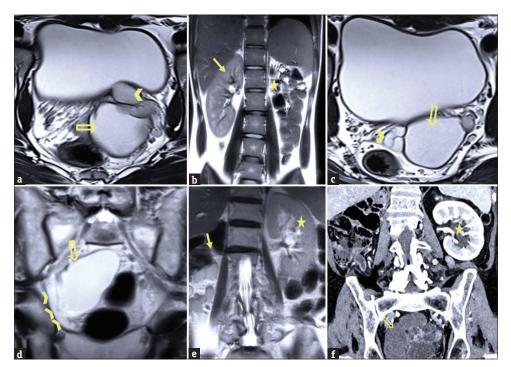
Magnetic resonance imaging (MRI) images of Zinner's syndrome, aka OSVIRA syndrome. (a-c) Constellation of features in Zinner's syndrome in case 3, (a) MRI T2 axial image showing left obstructed ejaculatory duct (blocked arrow) and left seminal vesicle cysts (arrowhead), (b) MRI T2 coronal image shows single right-sided kidney (arrow) and left renal agenesis (star), (c) MRI T2 axial image shows normal right-sided seminal vesicle (arrowhead) and left seminal vesicle cyst (blocked arrow), (d and e) MRI images of incidentally diagnosed case of Zinner syndrome, (d) MRI T2 coronal image shows dilated obstructed right ejaculatory duct (arrowheads) and right seminal vesicle cyst (blocked arrow), (e) MRI T2 coronal image shows solitary left kidney (star) with right renal agenesis (arrow), (f) Contrast-enhanced coronal computed tomography image showing solitary left kidney (star) and right seminal vesical cyst (arrow)
